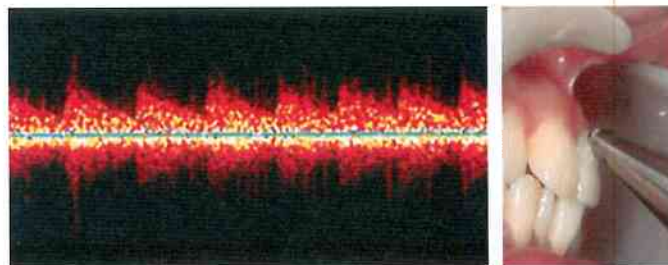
Typical Ultrasound Doppler graphy waveform in vital tooth (left) and the position of the measurement with a 20 MHz probe (right).
